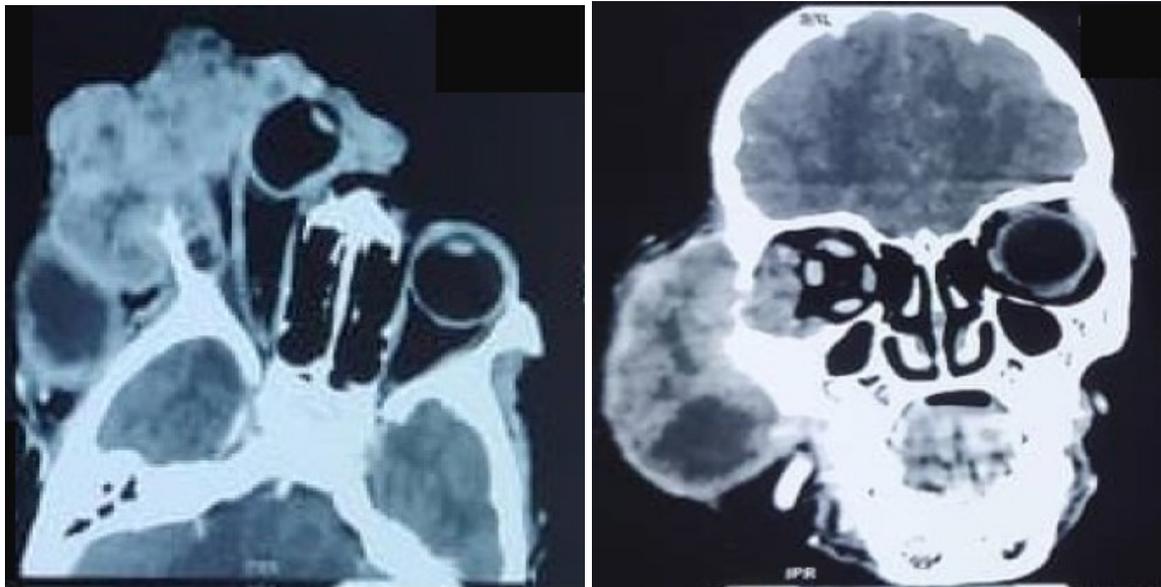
Right orbital mass invading the masseter muscles, the infraorbital soft tissues, lysing the zygomatic bone and infiltrating the infratemporal fossa on the axial et frontal orbito-cerebral CT scan.
